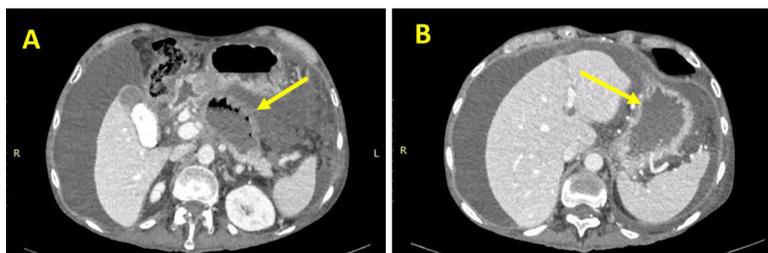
Multi-slice spiral computed tomography of the abdomen, with contrast. A) Pancreatic collection showing less volume than in previous images. B) Gastric chamber with adequate distension.
